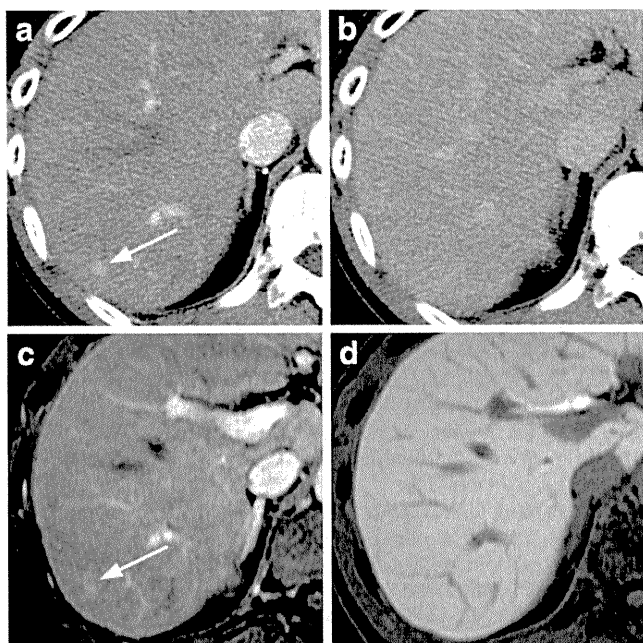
Images of hepatitis B cirrhosis in a 68-year-old-man. Contrast-enhanced CT image obtained during the arterial dominant phase (a) shows a mildly enhanced lesion, 8 mm in diameter, in the right liver lobe (arrow), which has become isoattenuating during the equilibrium phase compared with the surrounding liver parenchyma (b). Corresponding gadolinic acid-enhanced MR image obtained during the arterial dominant phase (c) shows a lesion 8 mm in diameter with slight enhancement (arrow). The MR image obtained during the hepatobiliary phase (20 min after contrast-medium administration), shows that the lesion has become isointense compared with the surrounding liver parenchyma (d). On CT images, one reader assigned this lesion a confidence score of 0, one assigned it a score of 1, two assigned it a score of 2 and one a score of 4. On both dynamic MR images alone and combined dynamic and hepatobiliary phase MR images, all the readers assigned it a score of 0. On CTAP images, this lesion did not show a perfusion defect, and on follow-up CT images obtained 3 months later, the hyperattenuation observed during the arterial dominant phase was not seen. This lesion was therefore considered to be an arterial enhancing pseudolesion
